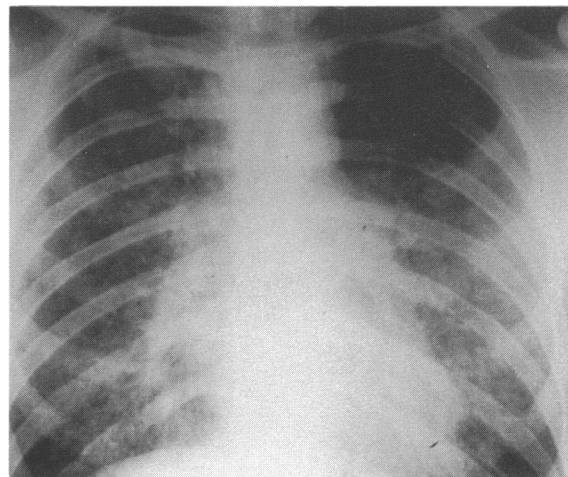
Chest radiograph of Case 1 showing diffuse bilateral micronodular shadows
